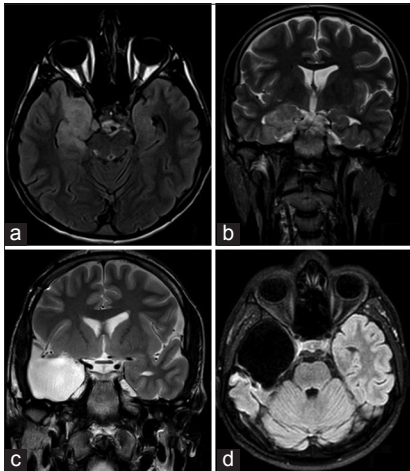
A 41-year-old female with dysembryoplastic tumor on the left mesial temporal area. The tumor had involved uncus and amygdala on axial fluid-attenuated inversion recovery (FLAIR) image (a) and coronal T2-weighted images (b). Temporal neocortex and the hippocampal + parahippocampal complex appeared normal. Radiological examinations at the last follow-up showed no tumor recurrence on coronal T2-weighted (c) and axial FLAIR (d) images and the patient was seizure-free.
